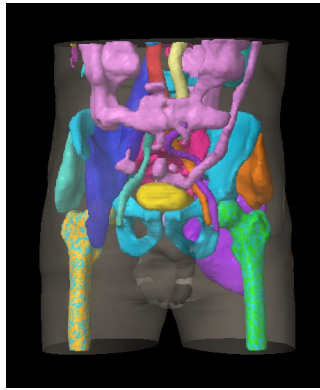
3D representation of a rectal cancer patient based on the planning CT. The body is contoured and internal structures are segmented using the auto-segmentation algorithm TotalSegmentator.
